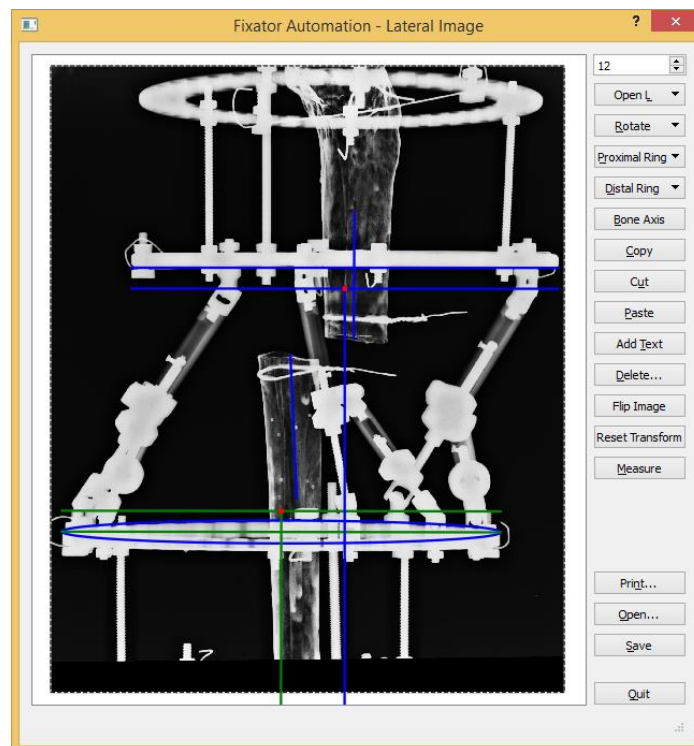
X-ray images of the fixator system from (a) *AP* and (b) *L* views.
